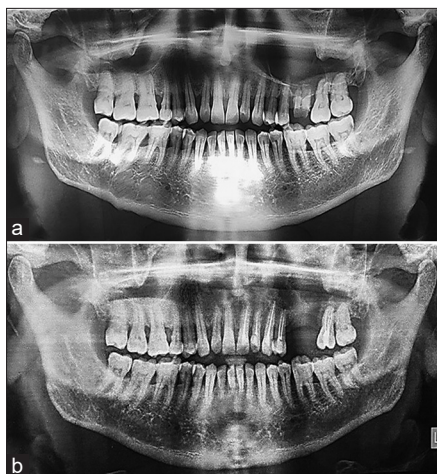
(a) Pre-operative orthopantomogram (OPG) of Case 1, showing a well-defined, unilocular radiolucency with well-defined corticated borders in the mandibular body, angle and ramus region of size 4 cm \times 3 cm with the presence of an impacted mandibular left third molar. (b) Post-operative OPG at 9-month follow-up, showing well-defined trabecular bone formation
